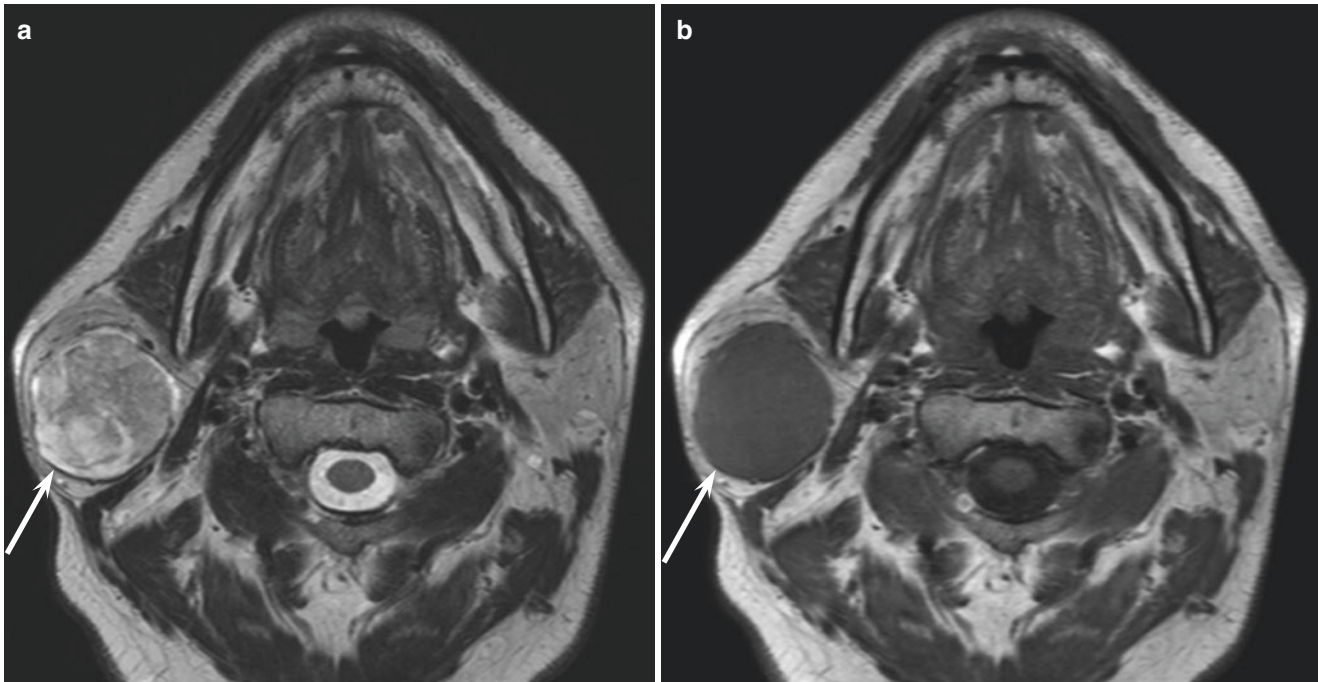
A 46-year-old man with carcinoma ex pleomorphic adenoma of the right parotid gland. (a) T2-weighted image shows a well-demarcated, heterogeneously hyperintense lesion (arrow). (b)
